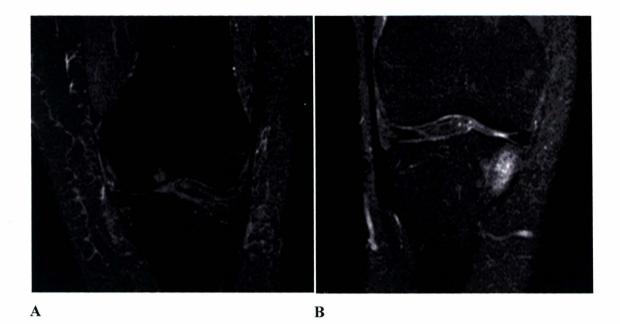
Coronal T_2 -weighted fat-saturated MRI images showing a large (A) and a very large (B) bone marrow lesion.
